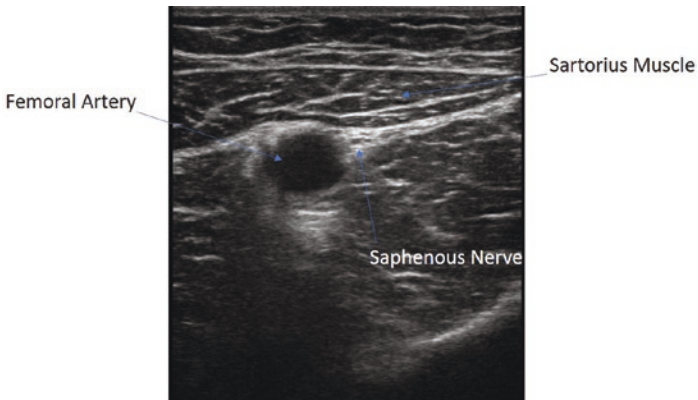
Ultrasound view of the adductor canal nerve block
